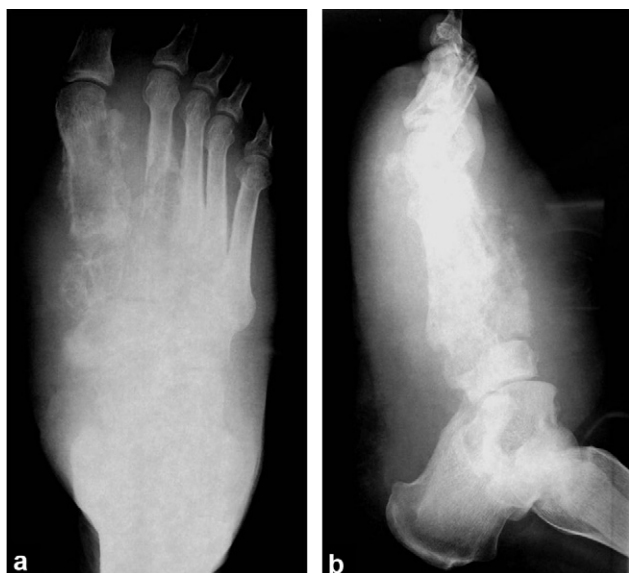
Radiography of the right foot, frontal (a) and lateral (b). Infiltration of the soft tissue, osteolysis of the cuneiform, navicular and first two metatarsal bones and an irregular periosteal reaction.
